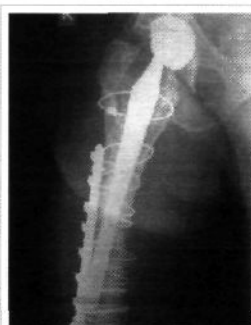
Case 1: Postoperative radiograph showing a cable plate applied to support a distal peri-prosthetic fracture
